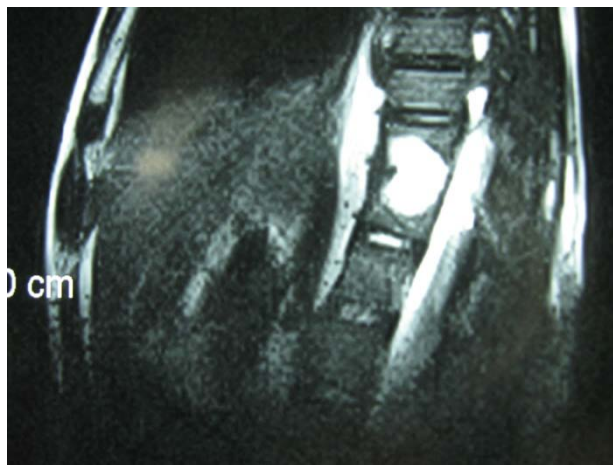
Midsagittal T2W MRI showing hyperintense lesion
